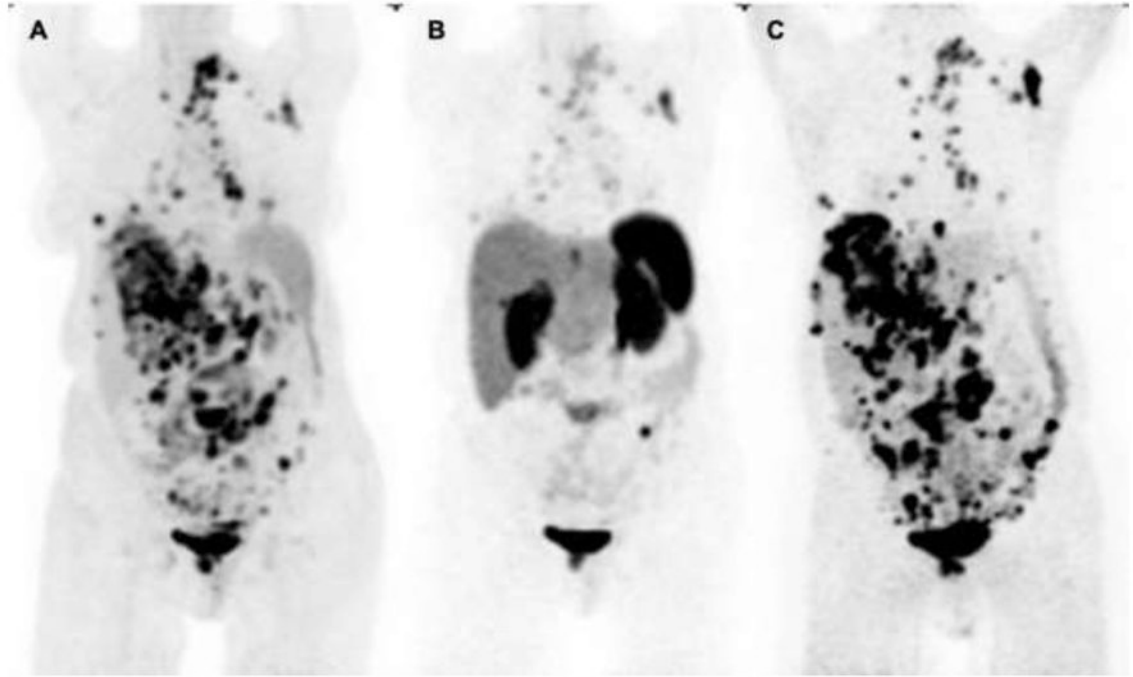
Selection of HSA-¹³¹I-MIBG over PRRT for metastatic PPGL based on superior norepinephrine transporter expression imaged by ¹²⁴I-MIBG PET/CT and compared with ¹⁸F-fluorodeoxyglucose PET/CT
